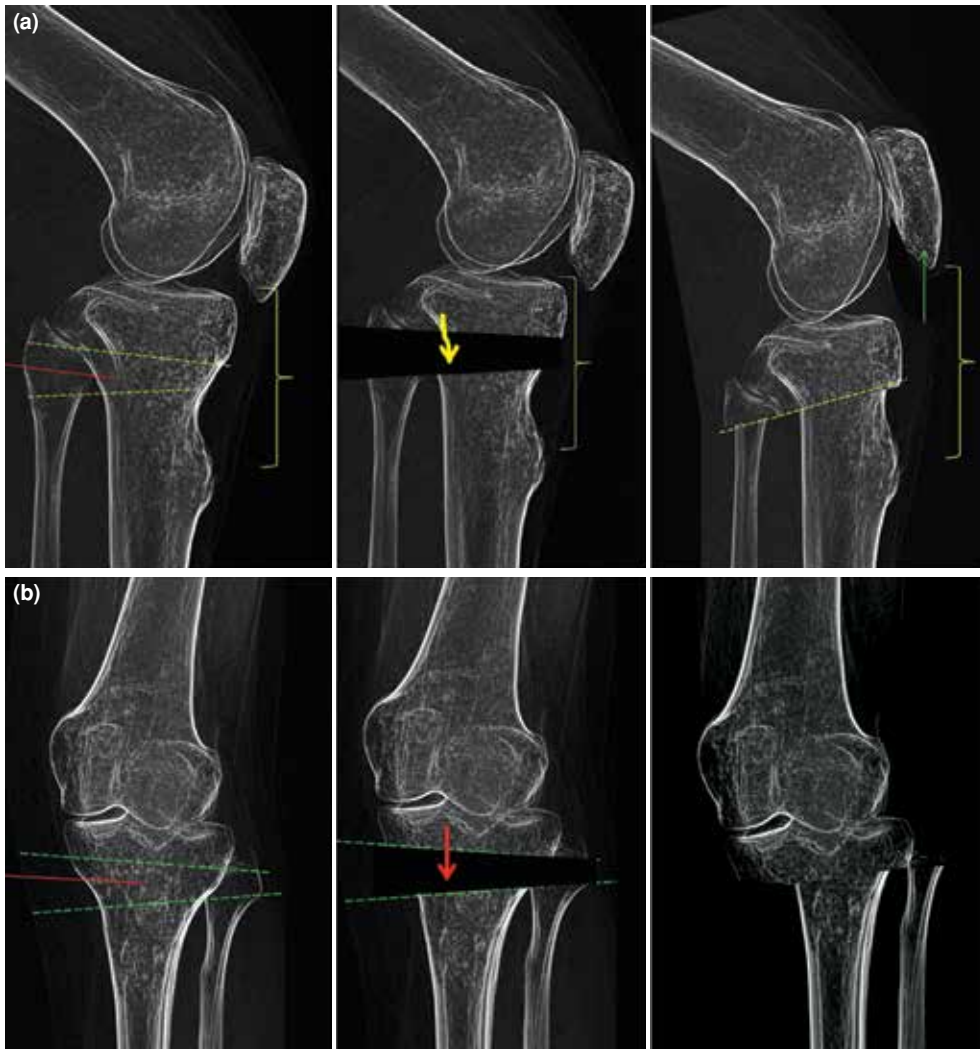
Planning of osteotomy on (a) lateral and (b) anterior-posterior radiographs.
